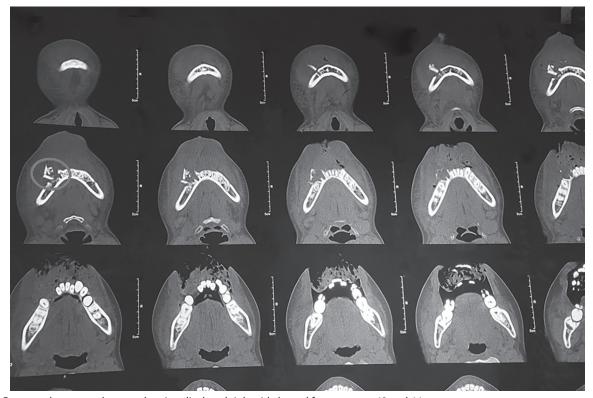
Computed tomography scan showing displaced right-side buccal fragment wrt 43 and 44
